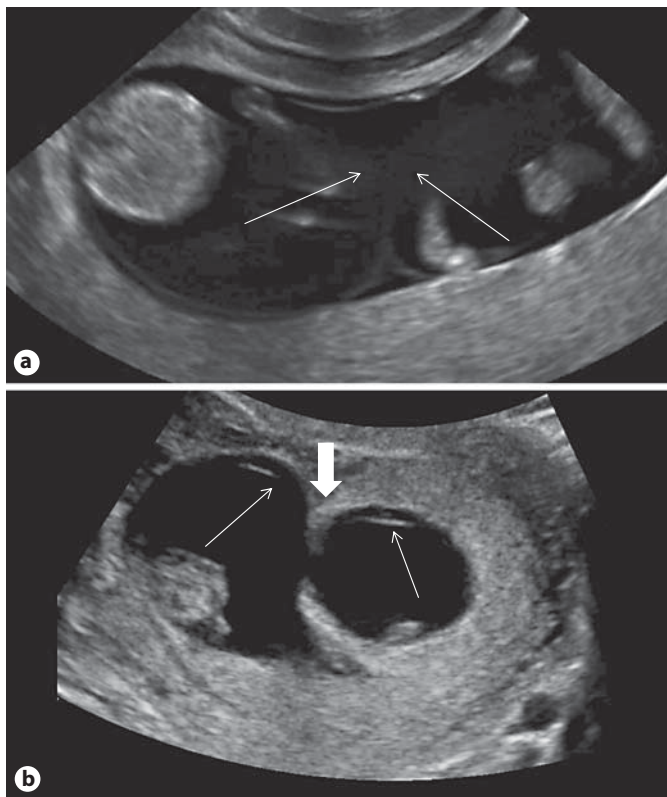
Chorionicity determination in the first trimester. a Ultrasound image of a monochorionic diamniotic twin pregnancy: the twins are separated only by two thin layers of amniotic membrane (thin arrows). b In dichorionic pregnancies, there are three layers separating the twins: two thin amniotic membranes (thin arrows) with a thick layer of chorion in between (thick arrow).
